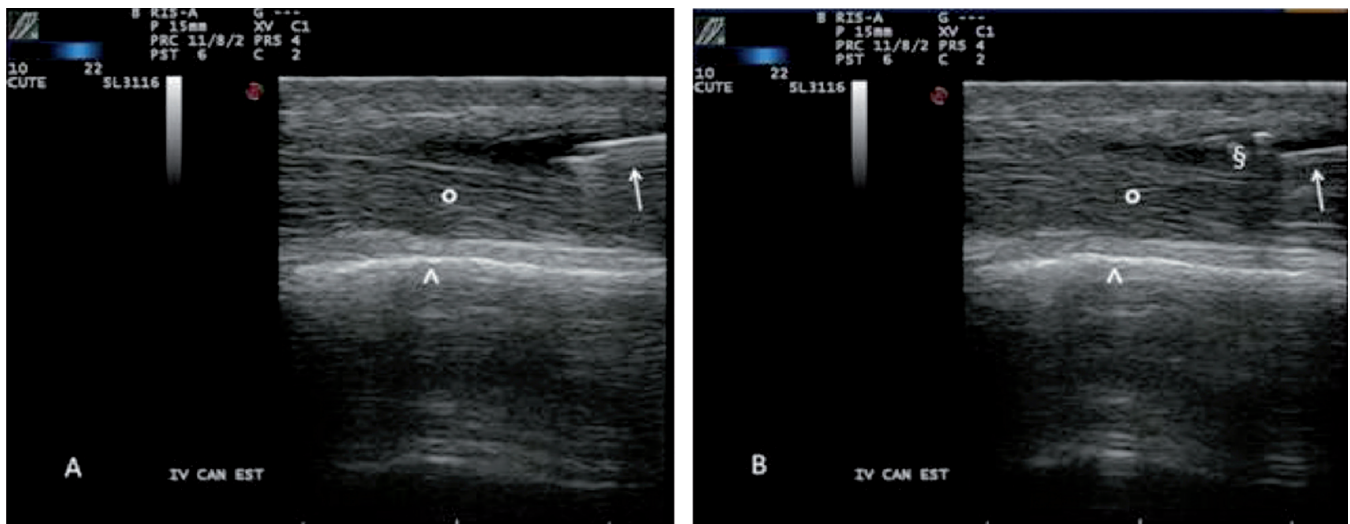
Ultrasound guided injection into the extensor tendon sheath of the wrist (compartment 4); dorsal longitudinal scan with 22 MHz probe.
